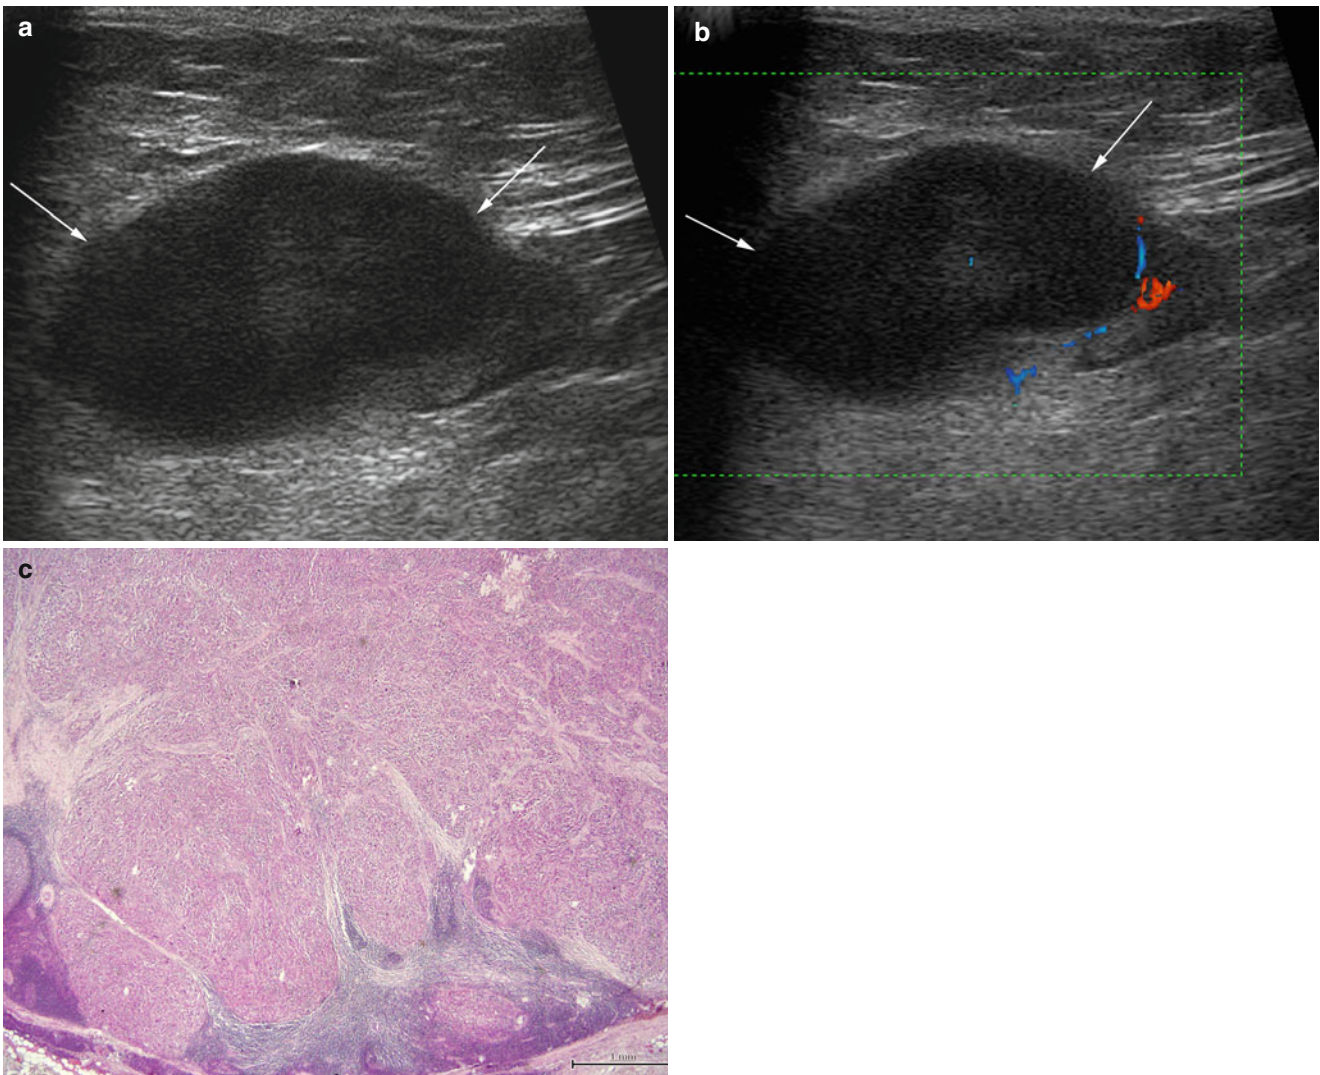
Metastatic lymph node. Large metastatic nodule within an inguinal lymph node (a, *arrows*). The color Doppler image (b) shows displaced hilar vessels and little vascularization of the nodule (*arrows*).
